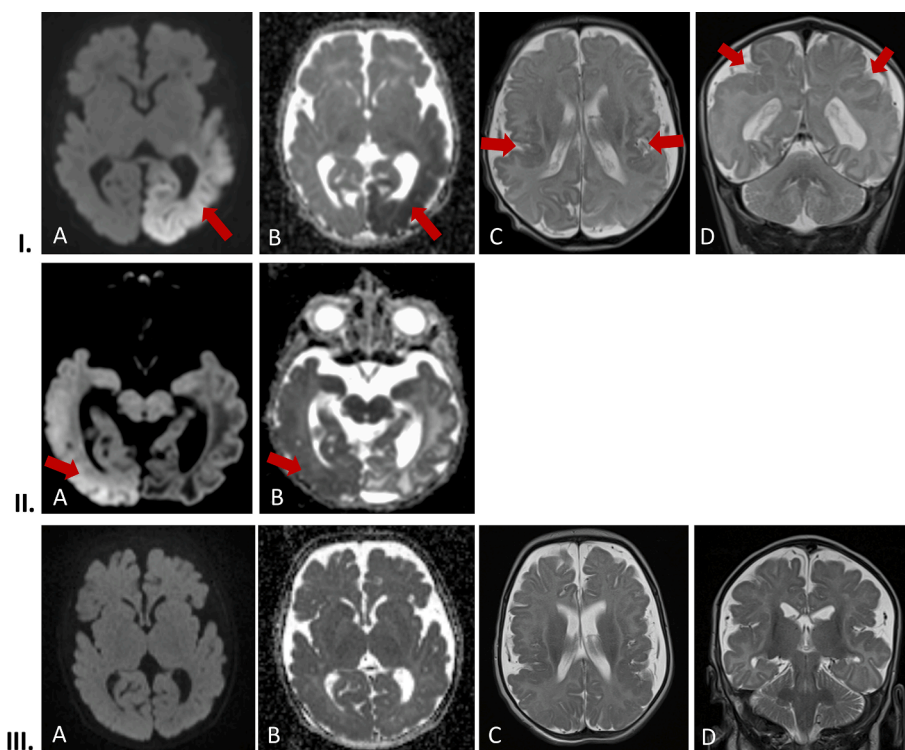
I. Brain MRI at day 2. A,B. Axial DWI (A), ADC map (B) show restricted diffusion on DWI with low ADC values in the left temporo-parieto-occipital cortex and subcortical white matter, without a specific arterial distribution; C,D. Axial (C) and coronal (D) T2-weighted image demonstrate a bilateral extensive perisylvian polymicrogyria extended to the pericentral region, as well as bilateral opercular dysplasia. II. A,B. Brain MRI acquired on day 9, one week after the first brain MRI. Axial DWI (A) image and ADC map (B) show a new area of reduced diffusivity in the right temporo-parieto-occipital cortex without a specific arterial distribution. Note the evolution of the prior left hemisphere injury, seen as a vasogenic oedema with increased ADC values. III. Brain MRI at day 2 after onset of status epilepticus at 2 months of age and 19 days. A,B. Axial DWI (A), ADC map (B) show no new restricted diffusion neither parenchyma lesion. C,D. Axial (C) and coronal (D) T2-weighted image demonstrate the known bilateral extensive perisylvian polymicrogyria extended to the pericentral region, as well as bilateral opercular dysplasia.
